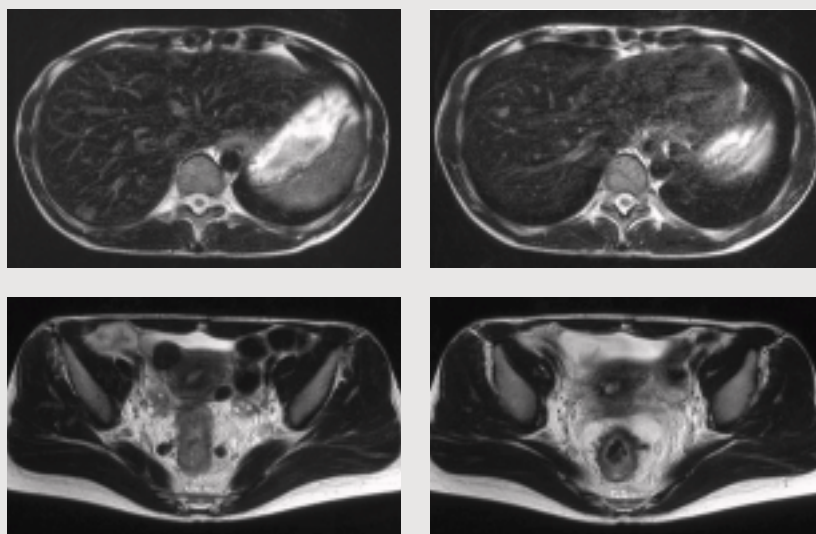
SPIO T2-weighted image
